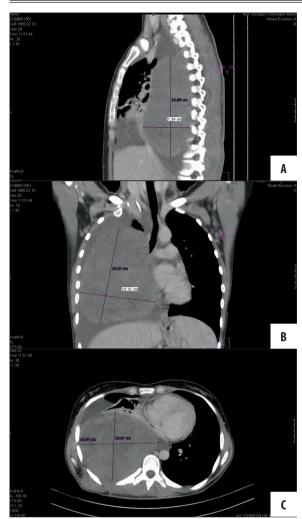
Chest CT scans showed multicentric giant desmoids, a tumour measuring 13×21 cm in the right pleural cavity that almost totally compressed the left lung, another one measuring 3.5×7.8×10 cm in the right hemithorax originating from the basis of the diaphragm, and a lesion measuring 3.5×4×4.5 cm located in the right abdominal wall.
